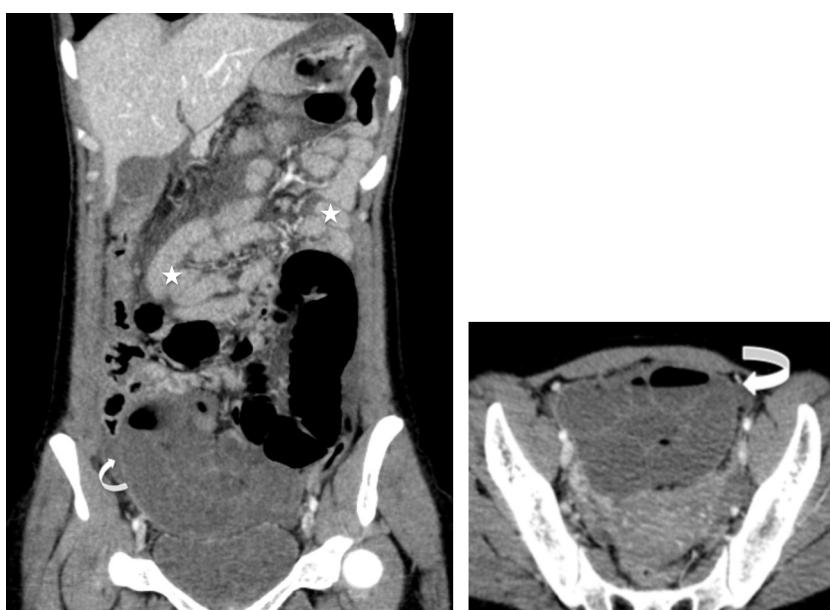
Flat belly obstruction: coronal (a) and axial CT image (b). Incarcerated loop distended in C (curved arrow). No distension upstream; flat jejunal loops (stars) (a). Lack of enhancement of the incarcerated loop and ascites attesting to intestinal necrosis (a, b).
